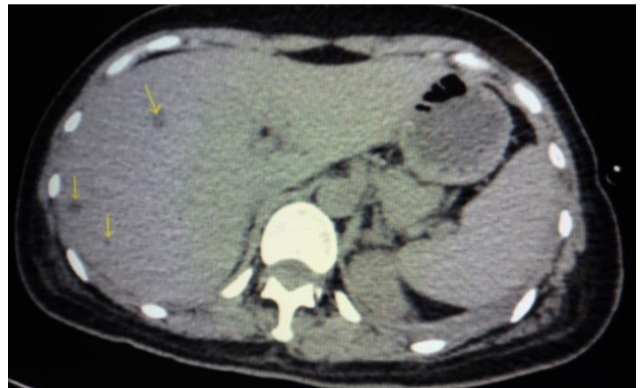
Whole abdominal CT scan showing multiple hepatic cysts
